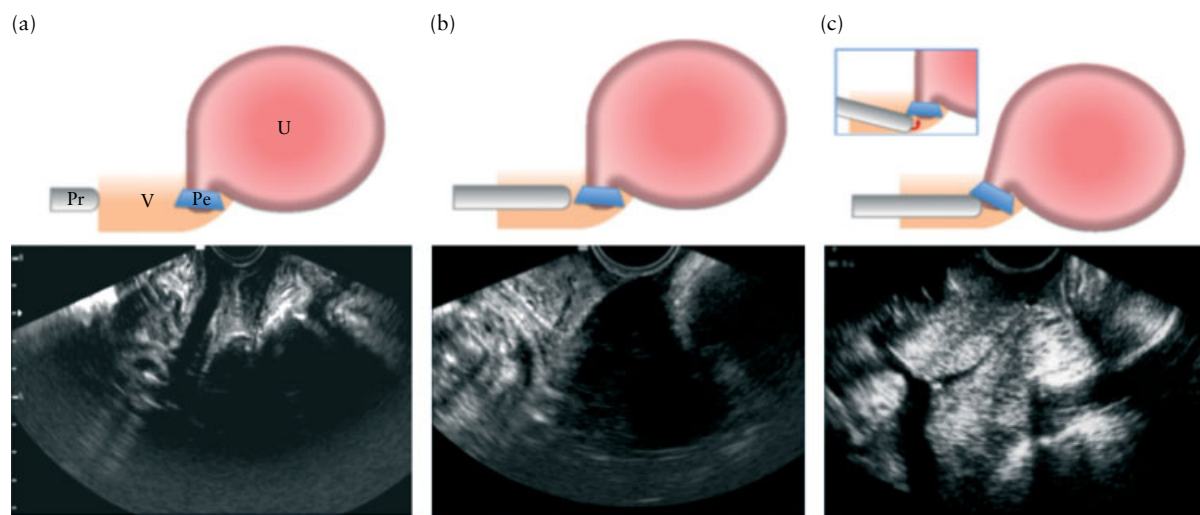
The three different approaches included in the study and the sonographic images they provide. (a) Transperineal measurement. (b) Transvaginal measurement with the probe in the anterior fornix (standard approach); note the shadow of the pessary in the corresponding ultrasound image. (c) The new transvaginal measurement approach proposed: with the probe just inside the pessary, a complete view of the cervical canal is obtained. Pe, pessary; Pr, probe; U, uterus; V, vagina.
